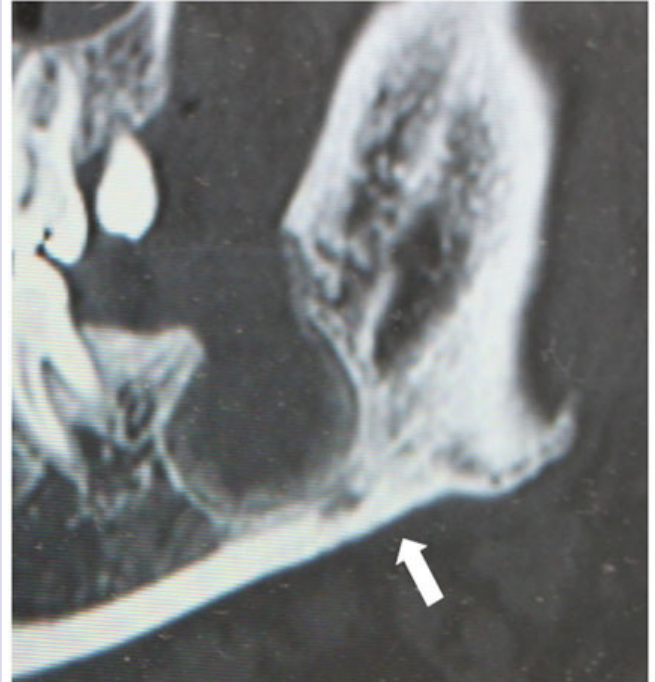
Bony union seen, 6 months later on CT. Fracture line disappeared (arrow).
